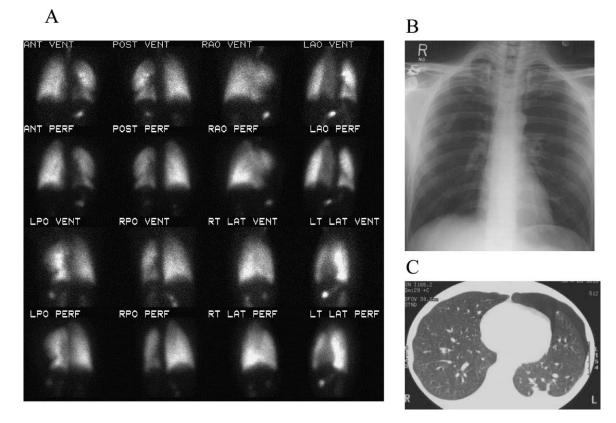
Tc-99m aerosol ventilation and Tc-99m macro-aggregated albumin (MAA) perfusion images of a young male showing generalized, mild matching decreased activity within the left hemithorax. No pleural based regions of ventilationperfusion (V/Q) mismatch to suggest acute pulmonary embolism (PE) were present. Chest radiograph (B) was interpreted as normal. Single transaxial slice from CT angiogram (C) shows a left pneumothorax with normal opacification of the pulmonary arteries.
